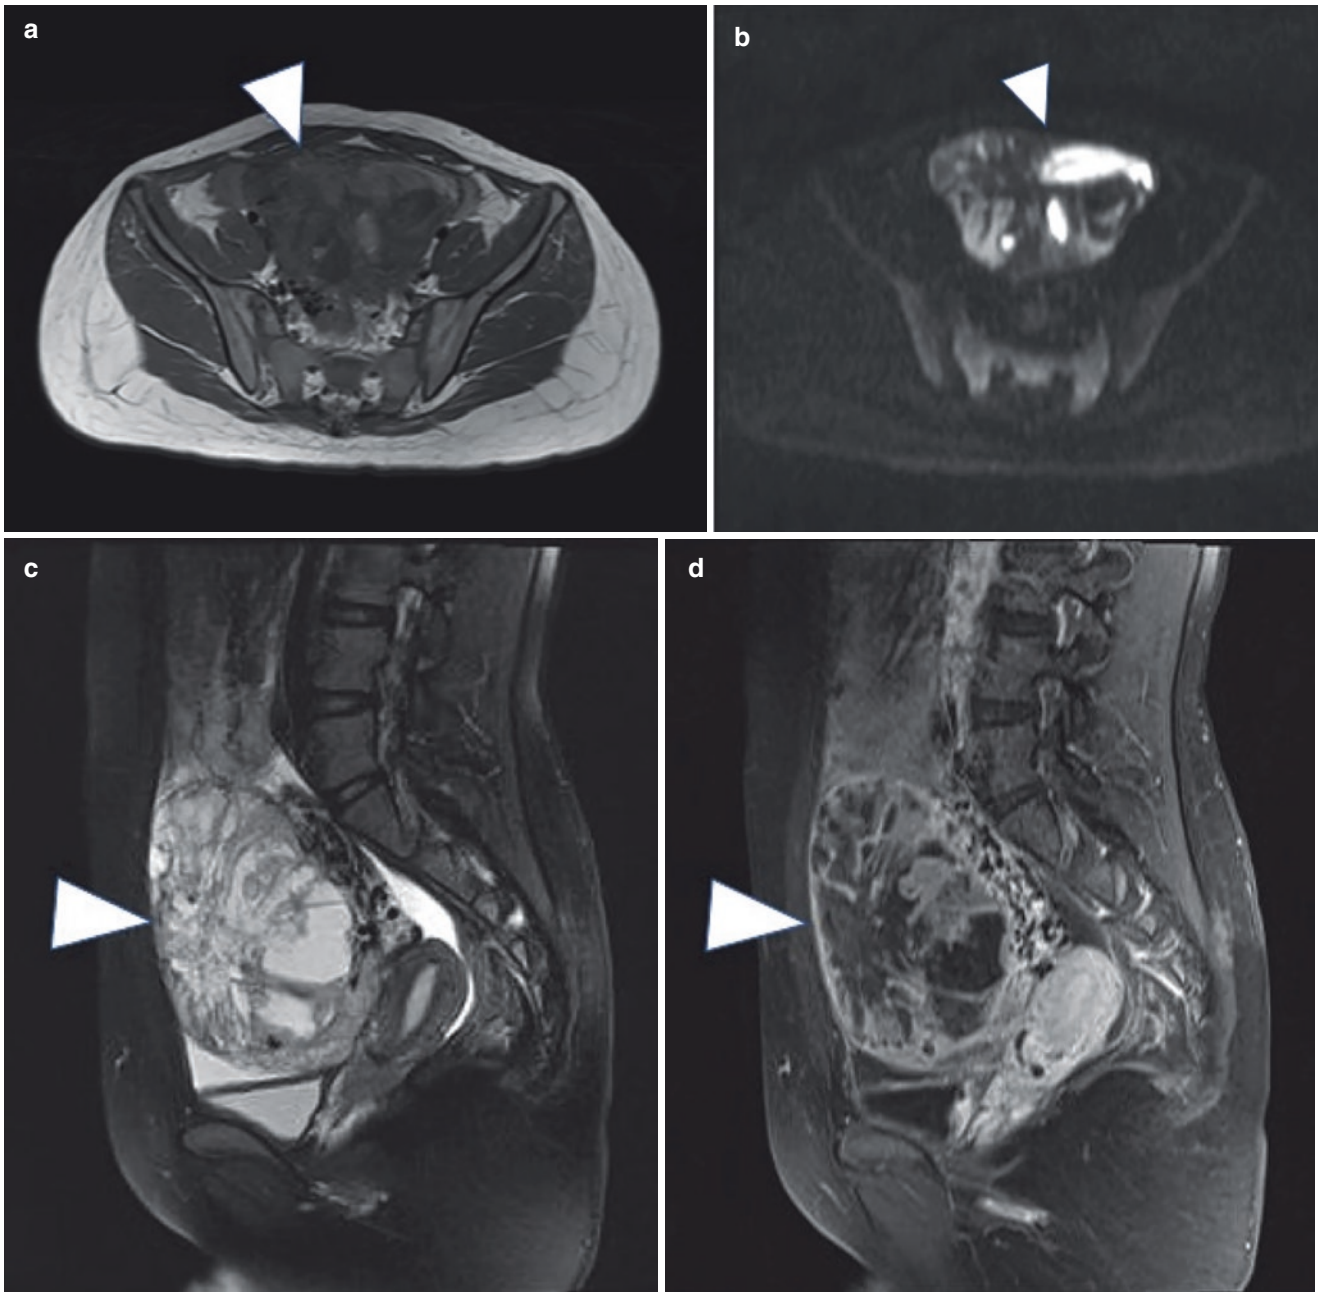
A 13-year-old girl with ovarian juvenile granulosa cell tumor. She complained of an irregular menstrual period for lasting almost 2 months, and ultrasound examination report in the outer hospital revealed a pelvic mass 10 days ago. A giant, cystic mass (arrowhead) displayed as mixed signal on both T1WI (a) and DWI (b). The multilocular components within the mass were evident on T2WI (c); the solid components enhanced avidly like the myometrium (d).
